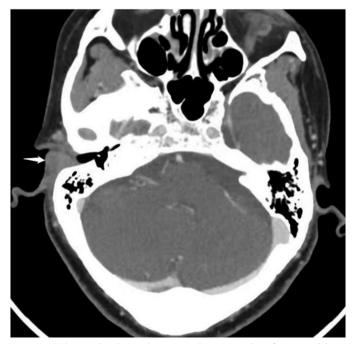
T he axial enhanced computed tomography of temporal bone shows enhanced soft tissue in the right cartilage segment of the posterior wall of the external auditory canal (white arrow).
